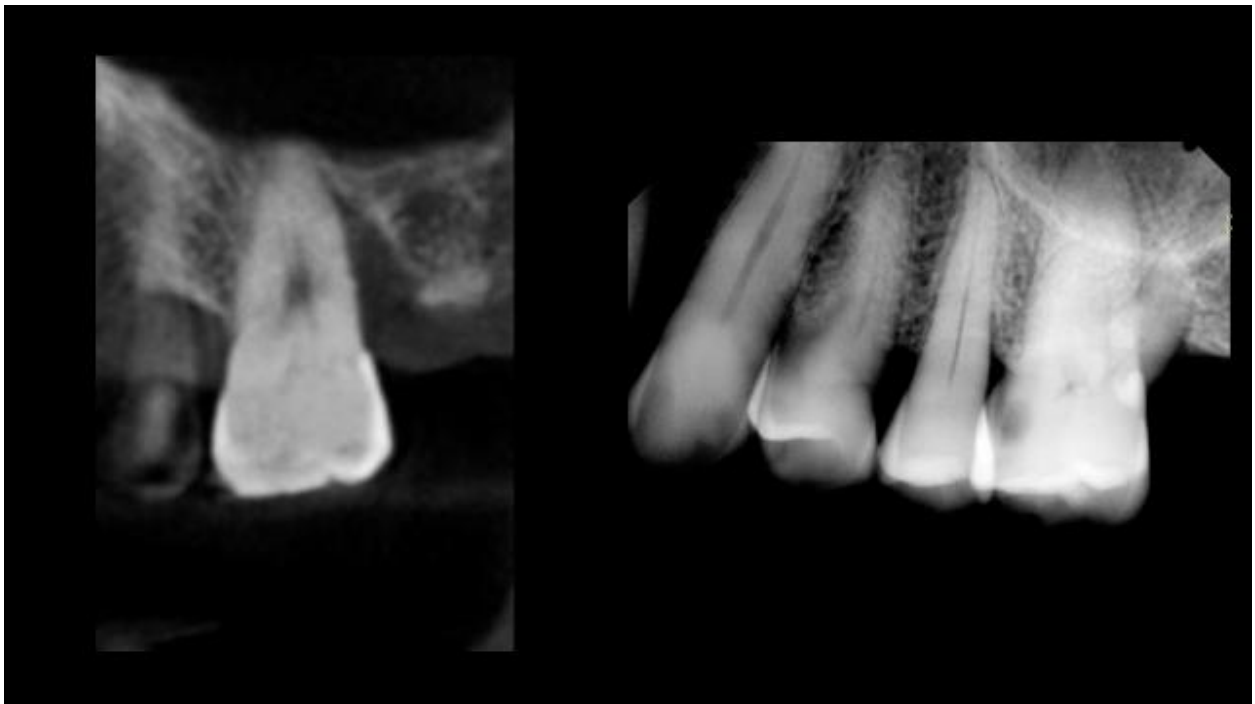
Distal vertical defect #14 CBCT (left) visible on PA (right)
